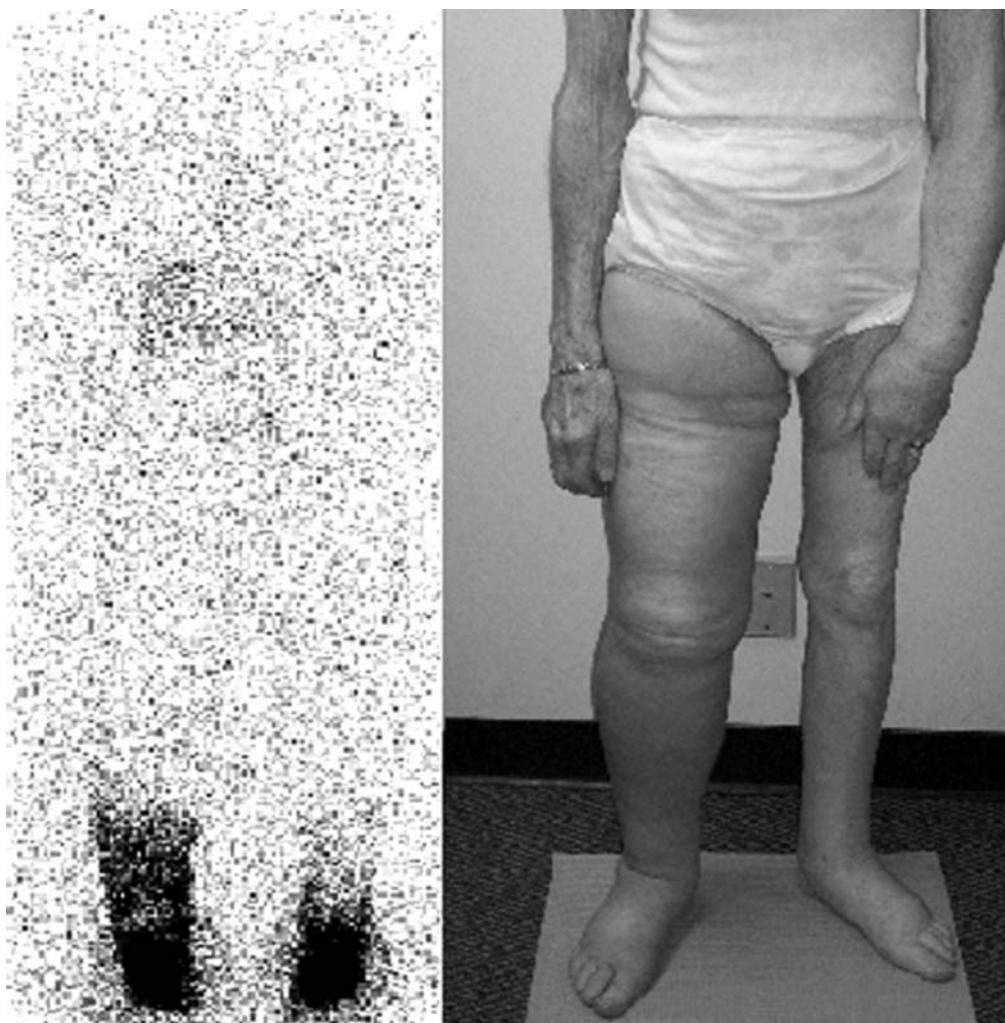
Right:* Chronic LE of right leg and left arm after pelvic and inguinal lymphadenectomy for uterine cancer and left axillary dissection for breast cancer, respectively. *Left:* Lymphoscintigram of lower extremities demonstrates poor overall lymphatic transit, with dermal backflow and retention, demonstrated commonly with ISL Stage II and III disease (Table 1).
